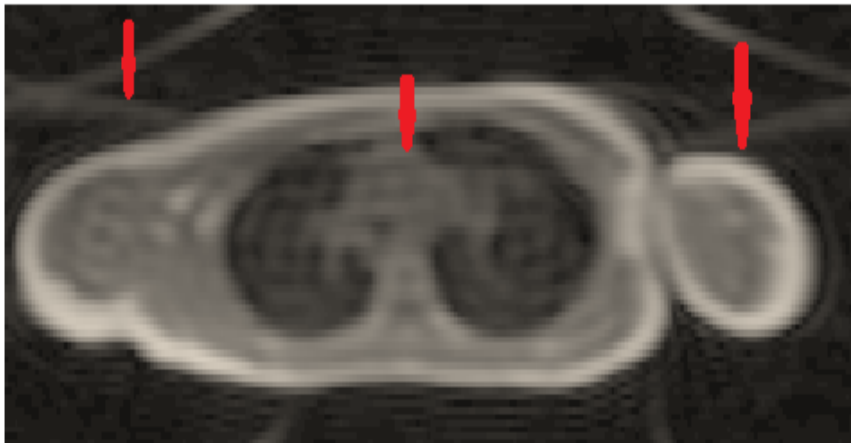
Shows an axial lung MR image which captured by protocol 1 with an artefact of horizontal lines, indicated by red arrows.
